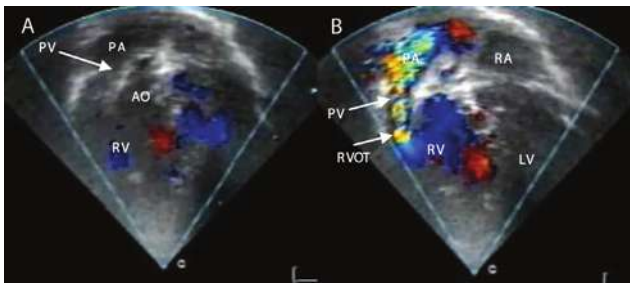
Apical 4-chamber view in case no. 4 : A. Double outlet right ventricle, the RV filled pulmonary artery through a narrow RVOT and PV annulus, B. turbulence was seen in pulmonary trunk - valvular and sub-valvular pulmonary stenosis. *LA – left atrium, RA – right atrium, LV– left ventricle, RV–right ventricle, PA–pulmonary artery, PV – pulmonary valve, RVOT – right ventricle outflow tract.*
